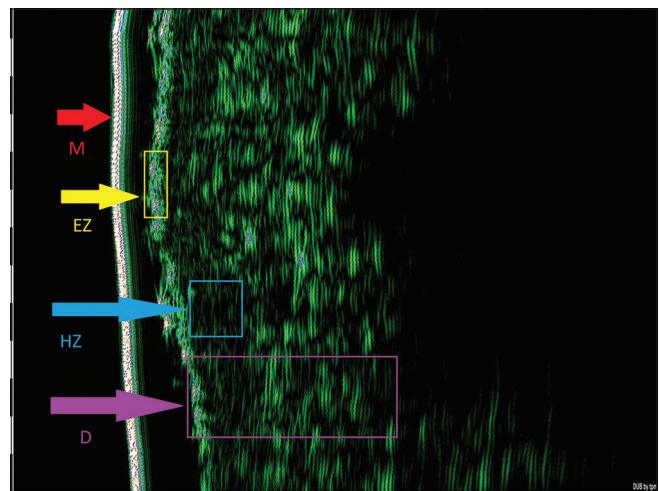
Infiltration in the dermis. Characteristic pattern of the hypoechogenic shadow (hypoechogenic zone, HZ) (sonographic image, 22.5 MHz); M-membrane, E-entry zone, HZ-hypoechogenic zone, D-dermis.
